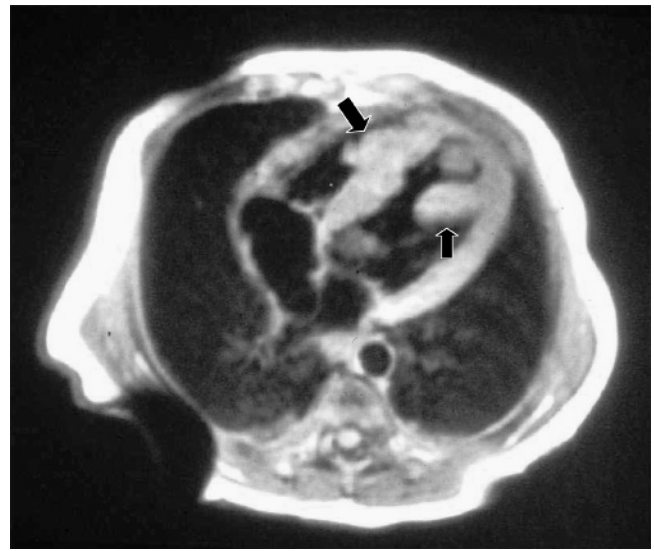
Magnetic resonance image showing cardiac rhabdomyomas infiltrating the ventricular septum and protruding into the right ventricle (arrows).
